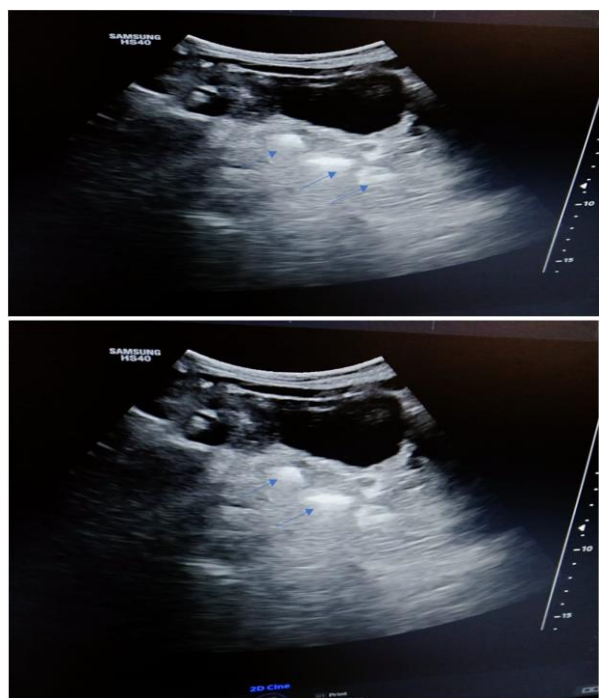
(a,b): Abdominal ultrasound image, of pediatric patient with chronic constipation showing fecal impaction
